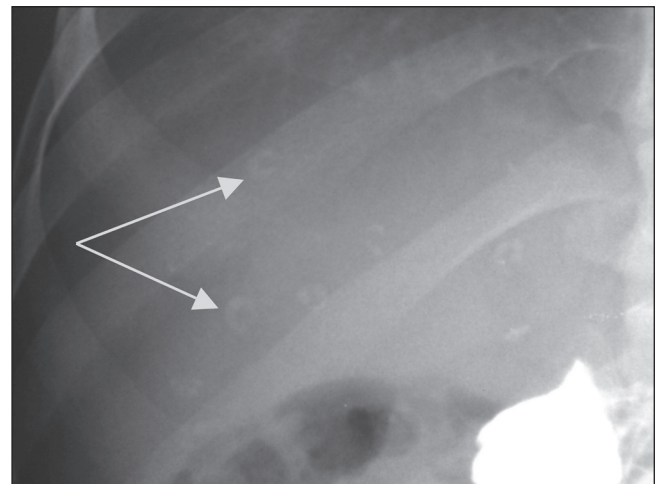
Plain X-ray of the liver (following barium meal) demonstrates the numerous comma-shaped calcified nymphs of *Armillifer armillatus*.
